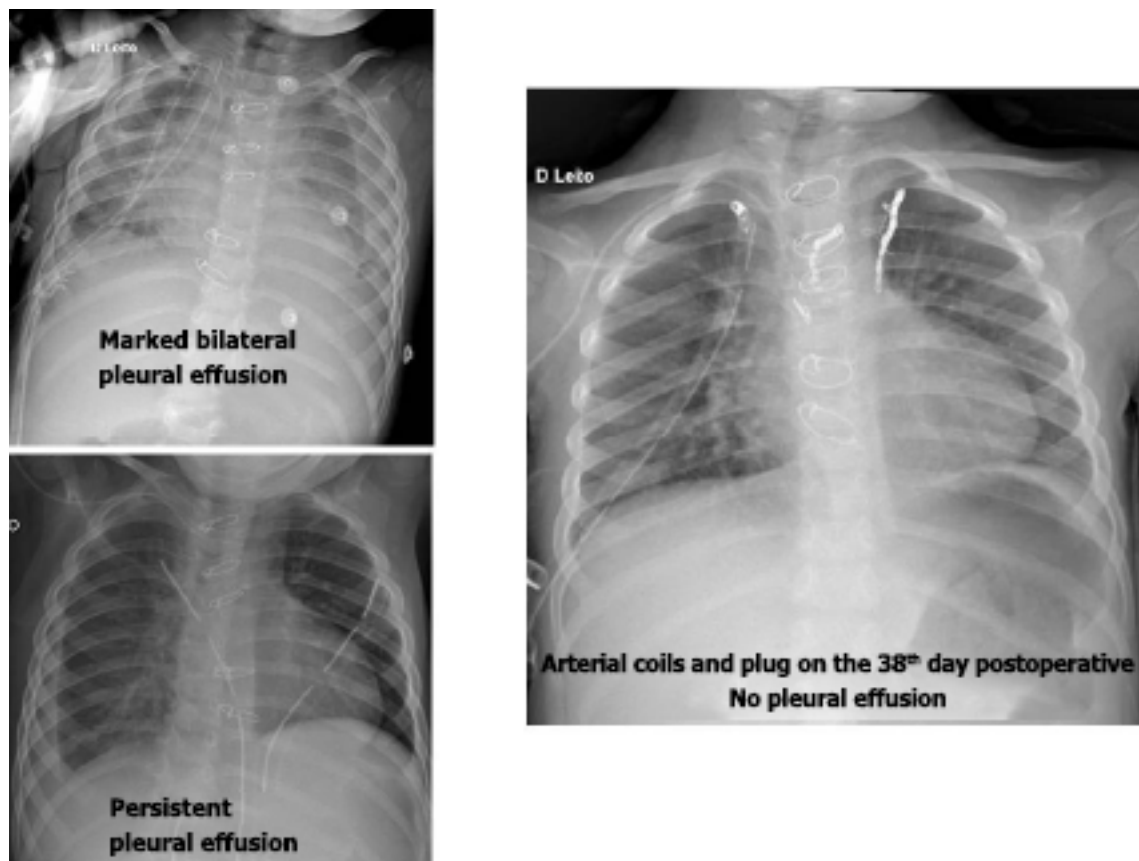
Chest x-rays in the postoperative period of cavopulmonary surgery in complex heart disease. The two images on the left depict the pleural effusions and the one on the right shows after the placement of arterial coils and plug in the demonstration of the normal and hypertrophic cardiac area.
